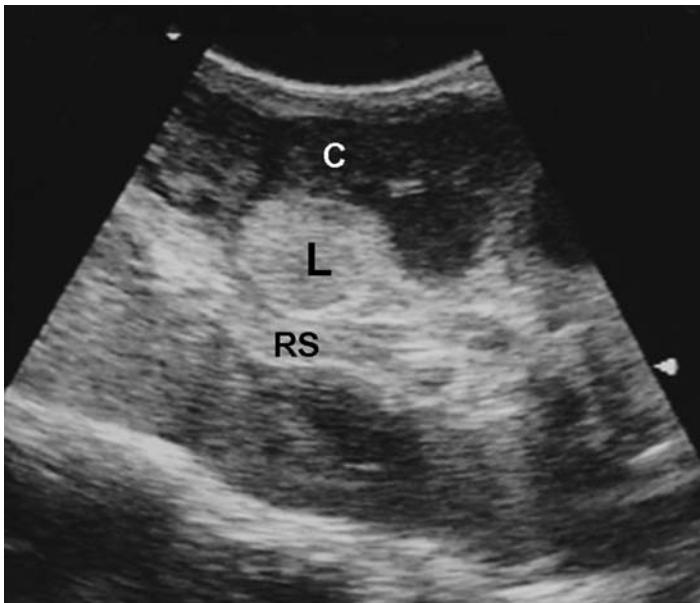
Intra-operative ultrasound of a patient with von Hippel-Lindau syndrome demonstrates a solid renal lesion (L) deep to the surface of the kidney and not visible to the surgeon. RS = renal sinus, C = renal cortex.
